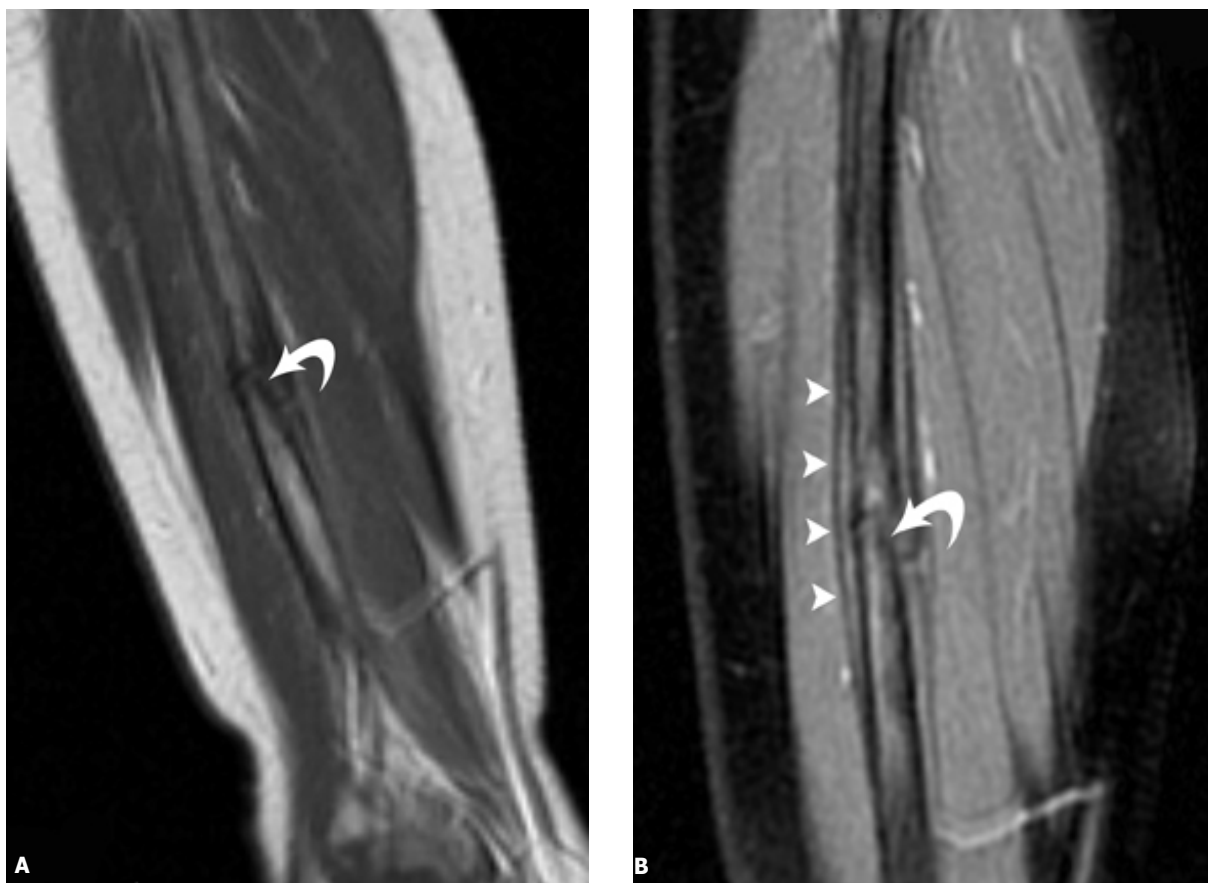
26-month-old boy with limp and subsequent fall. A, Sagittal TI-weighted (383/a) spin echo MRI of left fibula demonstrating a fracture line (curved arrow). B, Sagittal proton-density weighted (2500/29) fast spin echo (ETL6) MRI of the left fibula again demonstrating the fracture line (curved arrow) as well as periosteal elevation (arrowheads). This appearance is quite diagnostic of fracture.
